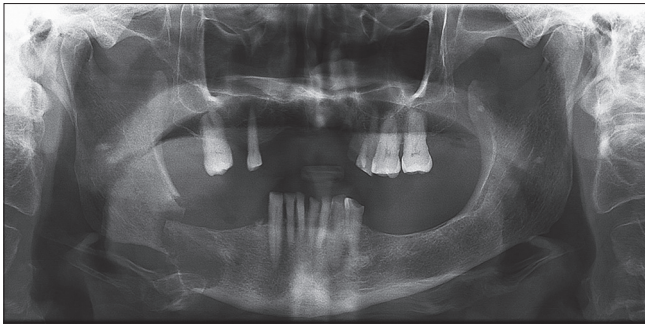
Orthopantomograph shows an ill-defined radiolucent lesion involving the body of the mandible with pathologic fracture
